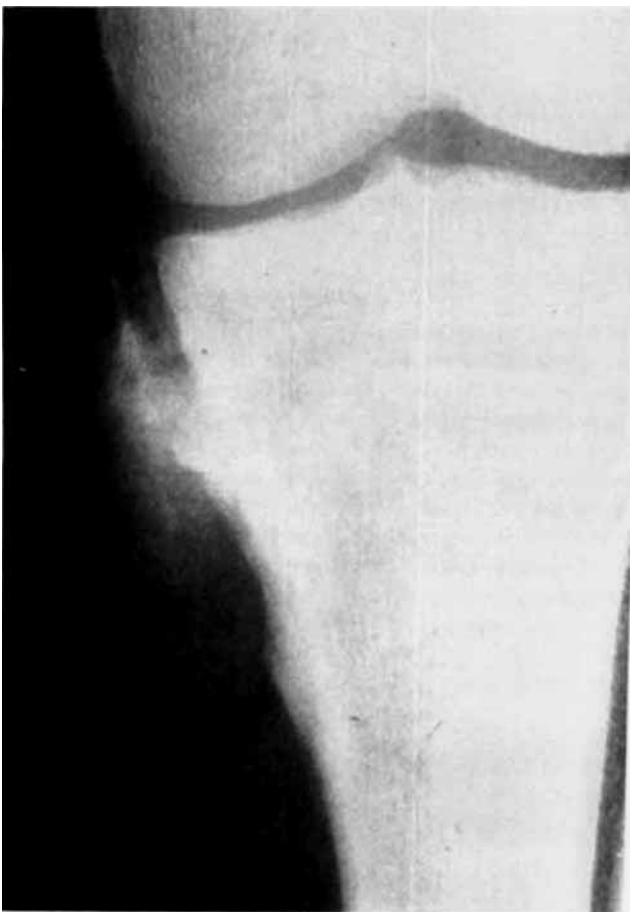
Preoperative roentgenogram of Case 1. This lesion of the right proximal tibia has its center on the periosteal surface. It has an ill-defined, partially mineralized soft tissue mass.
